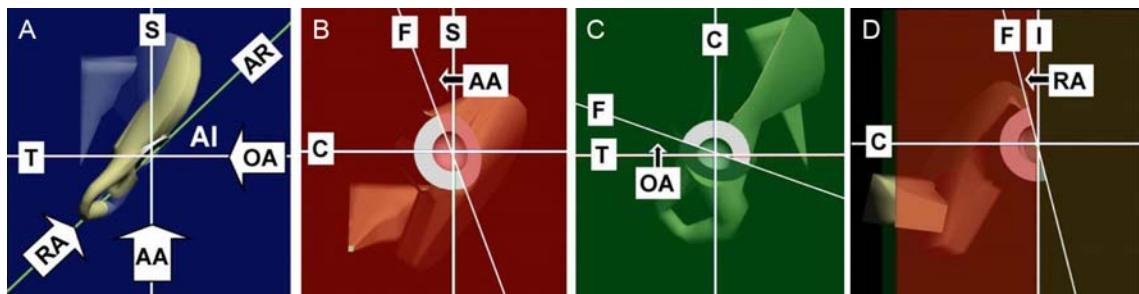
A: Demonstrate acetabular inclination (AI); direction for observation of anatomical anteversion (arrow AA), operative anteversion (arrow OA), and radiographic anteversion (arrow RA); axis of rotation of acetabular cup (AR)
